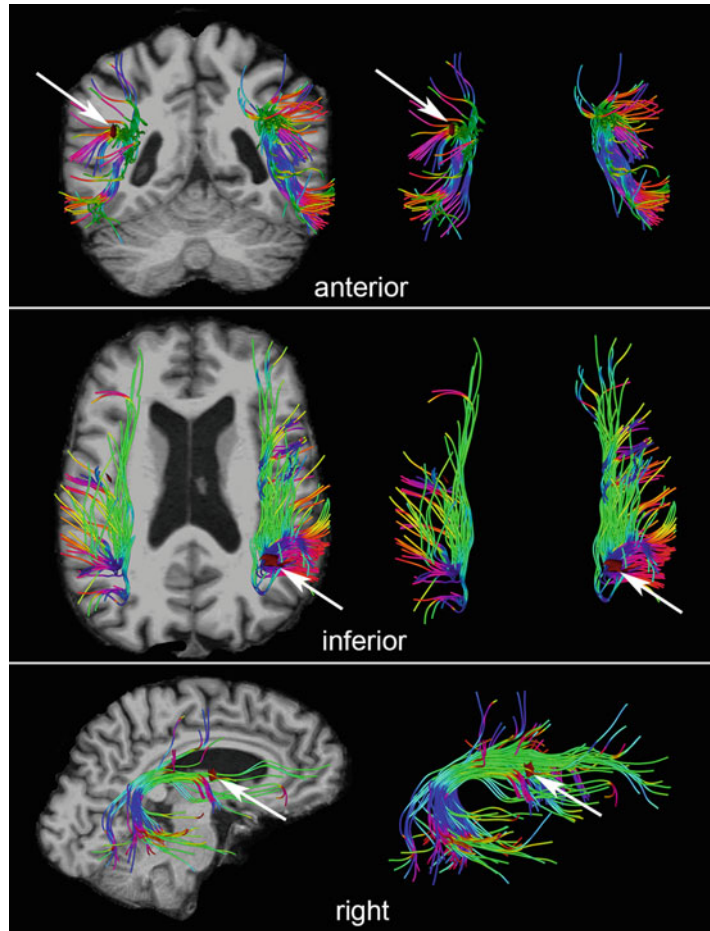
Example output of a DWI/SWI analysis revealing the colocalization of two CMBs (arrows) relative to the arcuate fasciculus (AF) of the two cerebral hemispheres. The AF is a WM structure with substantial involvement in speech production. Two CMBs are depicted as small, red, ovoidal objects located in the spatial vicinity of the AF. Shown are anterior (top row), inferior (middle row), and right (bottom row) views of the cerebral cortex, cerebellum, lateral ventricles and brain stem. Because of their locations, only one CMB is visible in any of the three views. Specifically, one (smaller) CMB is visible in the anterior and lateral views (top and bottom rows), and one (larger) CMB is visible in the inferior view (middle row). T_1 -weighted images of the cortex are overlaid to indicate the location of the CMBs and AF relative to the anatomy of the brain. WM streamline orientation is color-coded (red: left to right; green: anterior to posterior; blue: inferior to superior). The left column localizes the AF relative to the brain, whereas the right column isolates this WM structure for easier visualization
